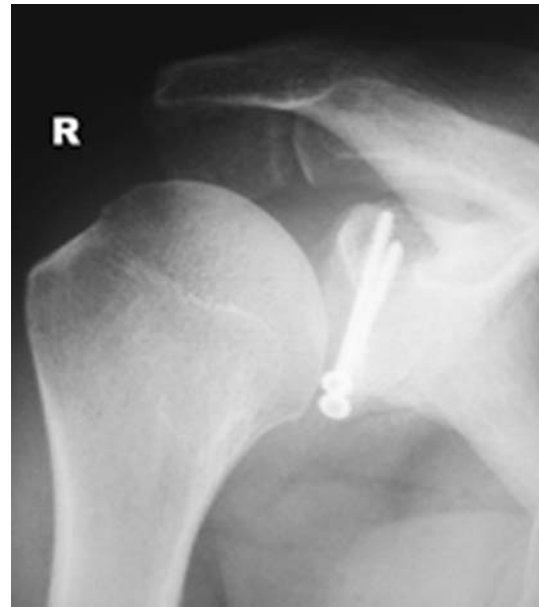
Immediate postoperative antero-posterior radiograph of a 32 years' old man after surgery treated with two cannulated screws
